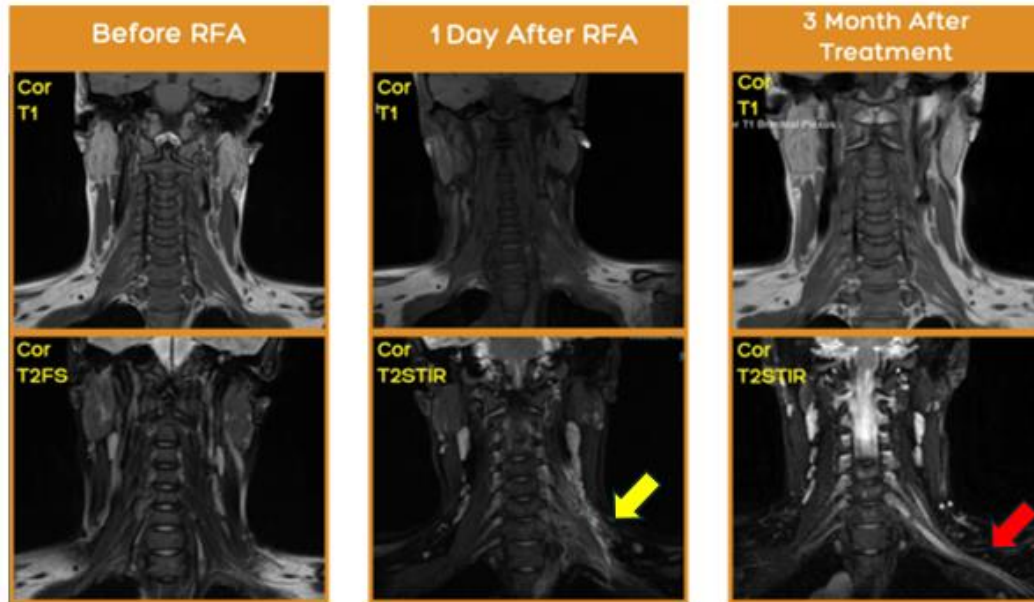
Cervical MRI comparison. Left: before RFA, no lesion or edema on left mid neck. Middle: 1 day after RFA, prominent edema around the lesion that extends to left mid neck and left brachial plexus (yellow arrow). Right: 3 months after treatment, edema was reduced but there was hyperintense on C5 and C7 level of brachial plexus (red arrow).
